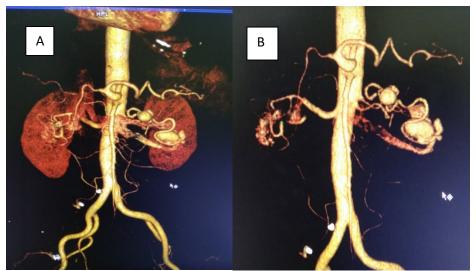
(Renal angiography): A & B 3D reconstructed CT angiography Images Show arteriovenous malformation mid third of right kidney and upper –to mid-third of left Kidney. Dilated feeding arteries in left kidney are seen
